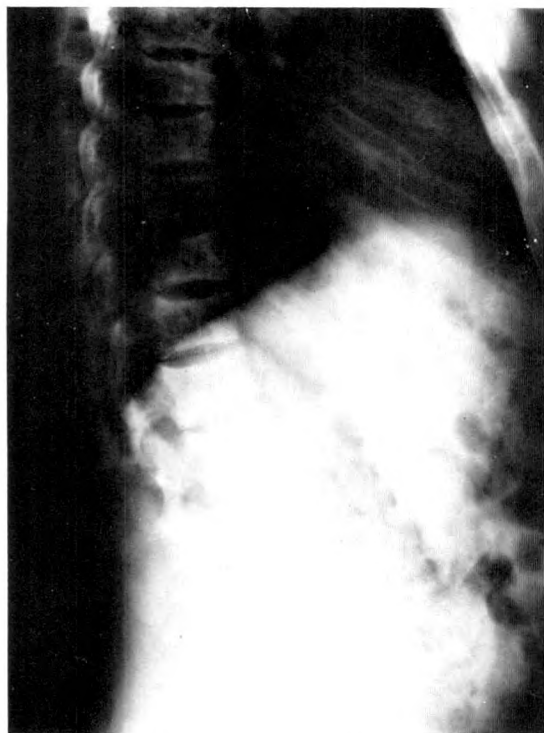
Lateral roentgenogram best demonstrates the earliest changes of the vertebral bodies.
